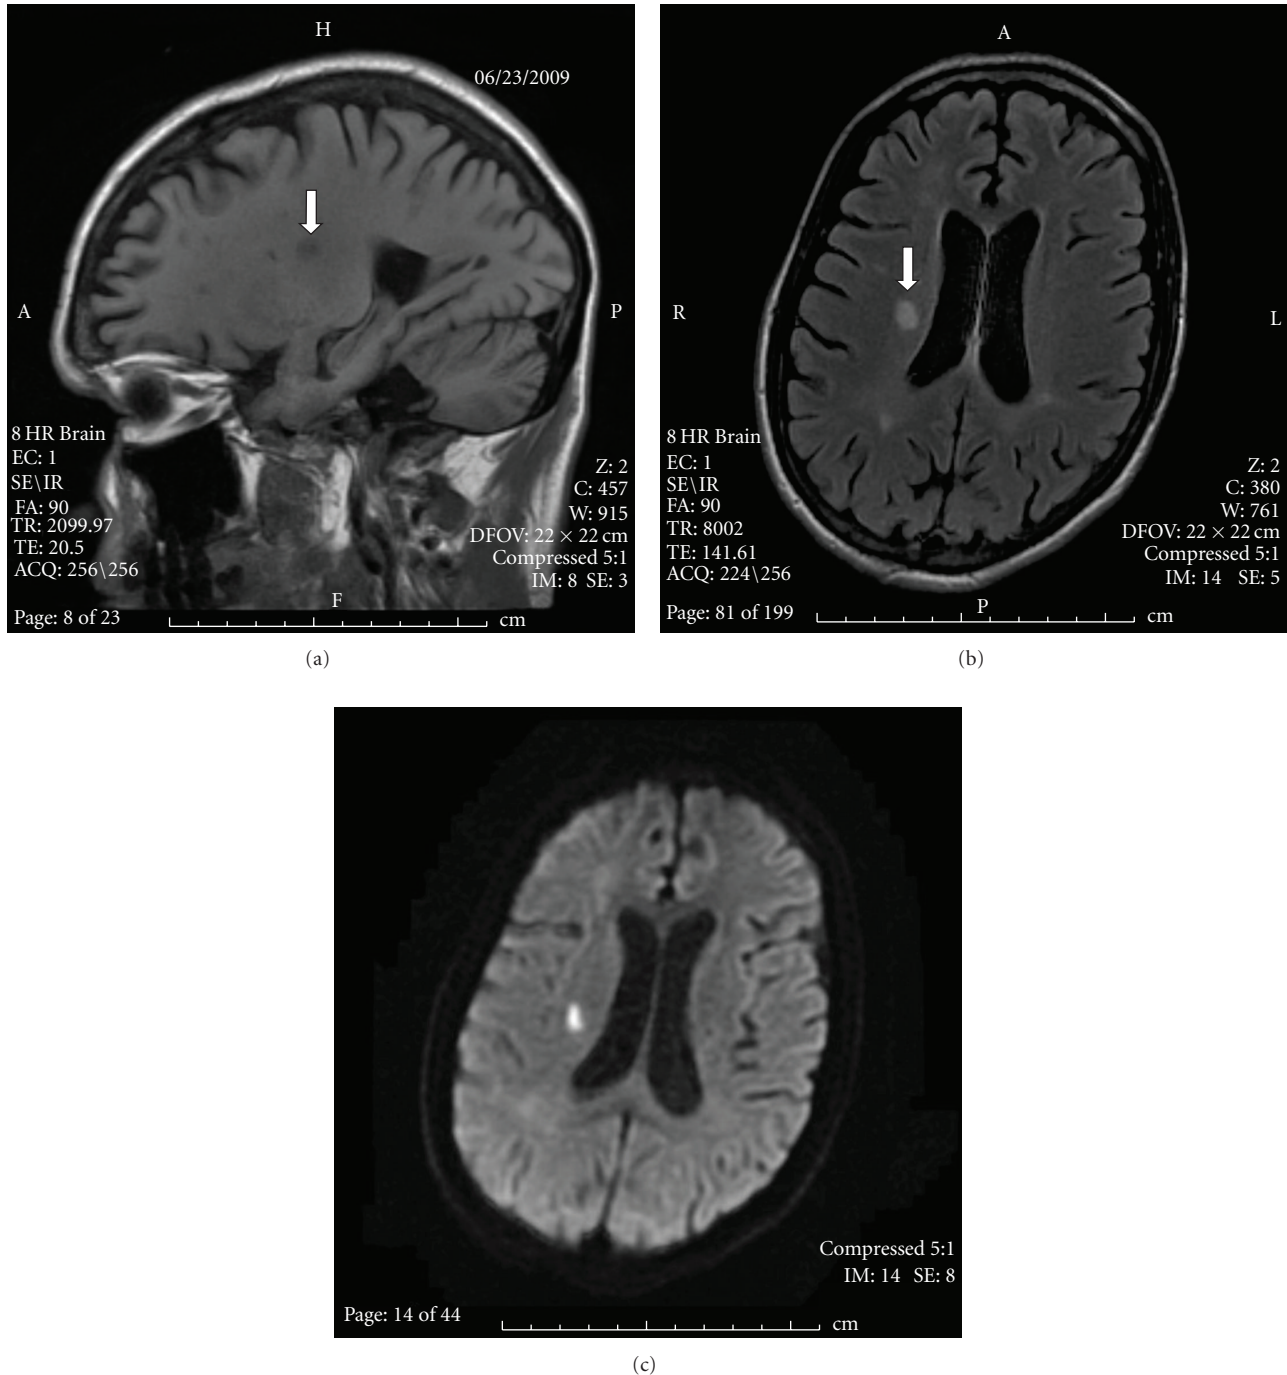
MRI of brain on presentation: (a) sagittal view showing acute right side frontal lobe infarct marked by arrow. (b) Axial view with same right side frontal lobe infarct marked by arrow. (c) Diffusion-Weighted Image of ischemic stroke in the right centrum semiovale.
